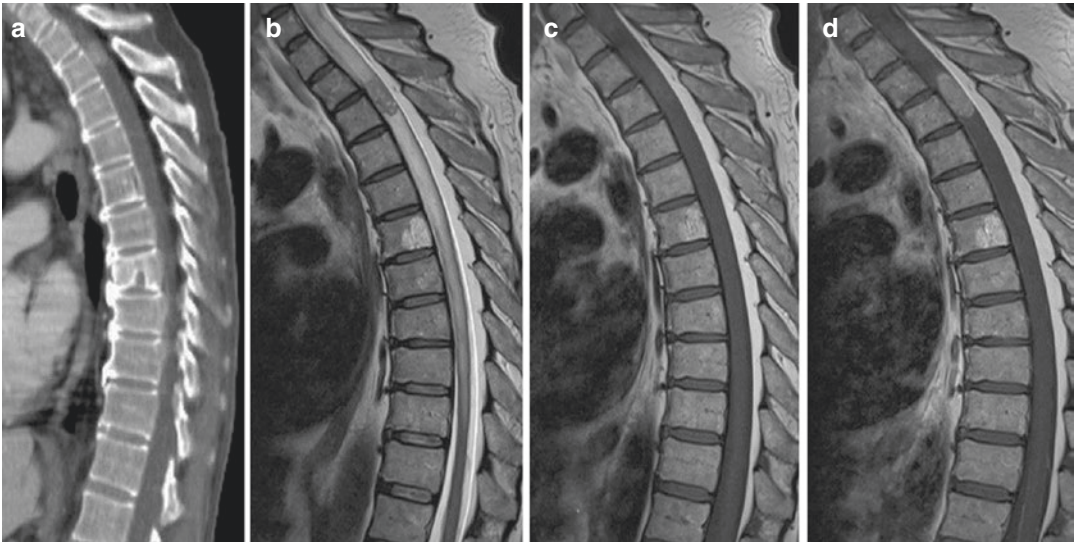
Spinal cord metastasis in male patient with disseminated lung carcinoma (one brain metastasis in pre-central gyrus). Sagittal CT (a), non-contrast T2WI (b) and T1WI (c), contrast-enhanced T1WI (d). Expansile solid lesion centrally located in the thoracic spinal cord:
